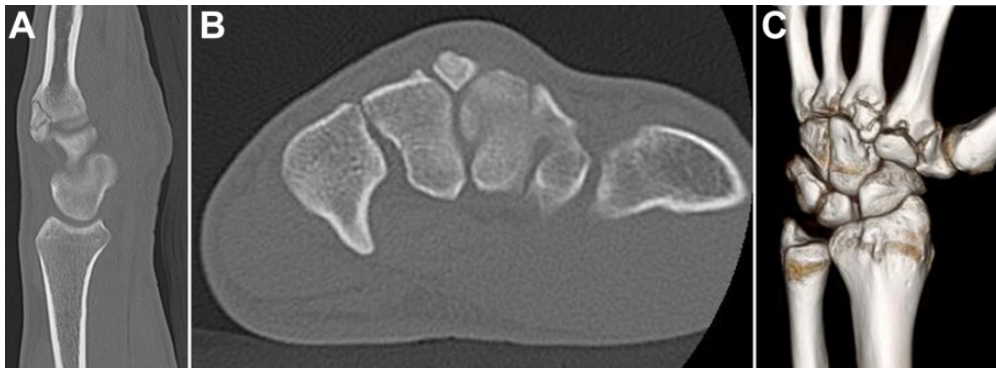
(A) Sagittal, (B) axial, and (C) 3-dimensionally reconstructed computed tomography images of a patient with a symptomatic carpal bossing of the second and third carpometacarpal joint complex.
